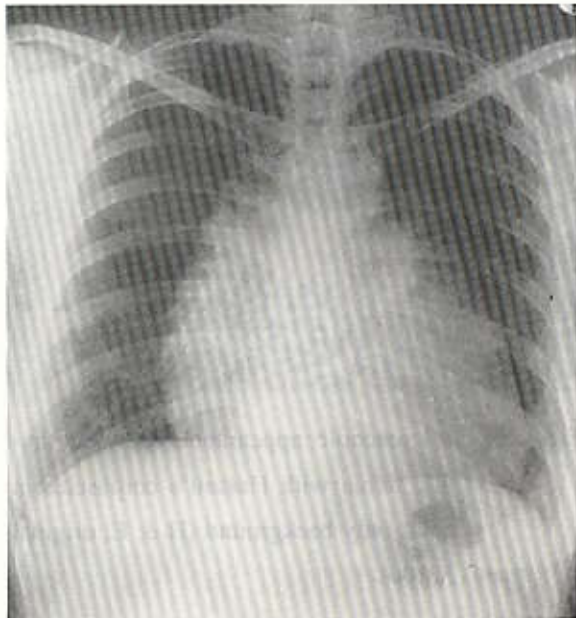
Postero-anterior chest radiograph showing a normal-sized heart with superimposed huge mass along the borders.
